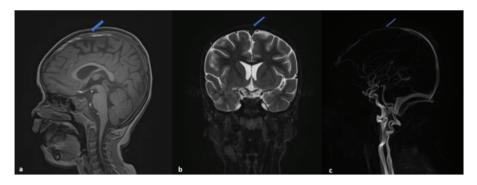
Brain MRI - Venous infarction secondary to sinus thrombosis: a) Sagittal section; b) Coronal section; c) Blood vessel section.
